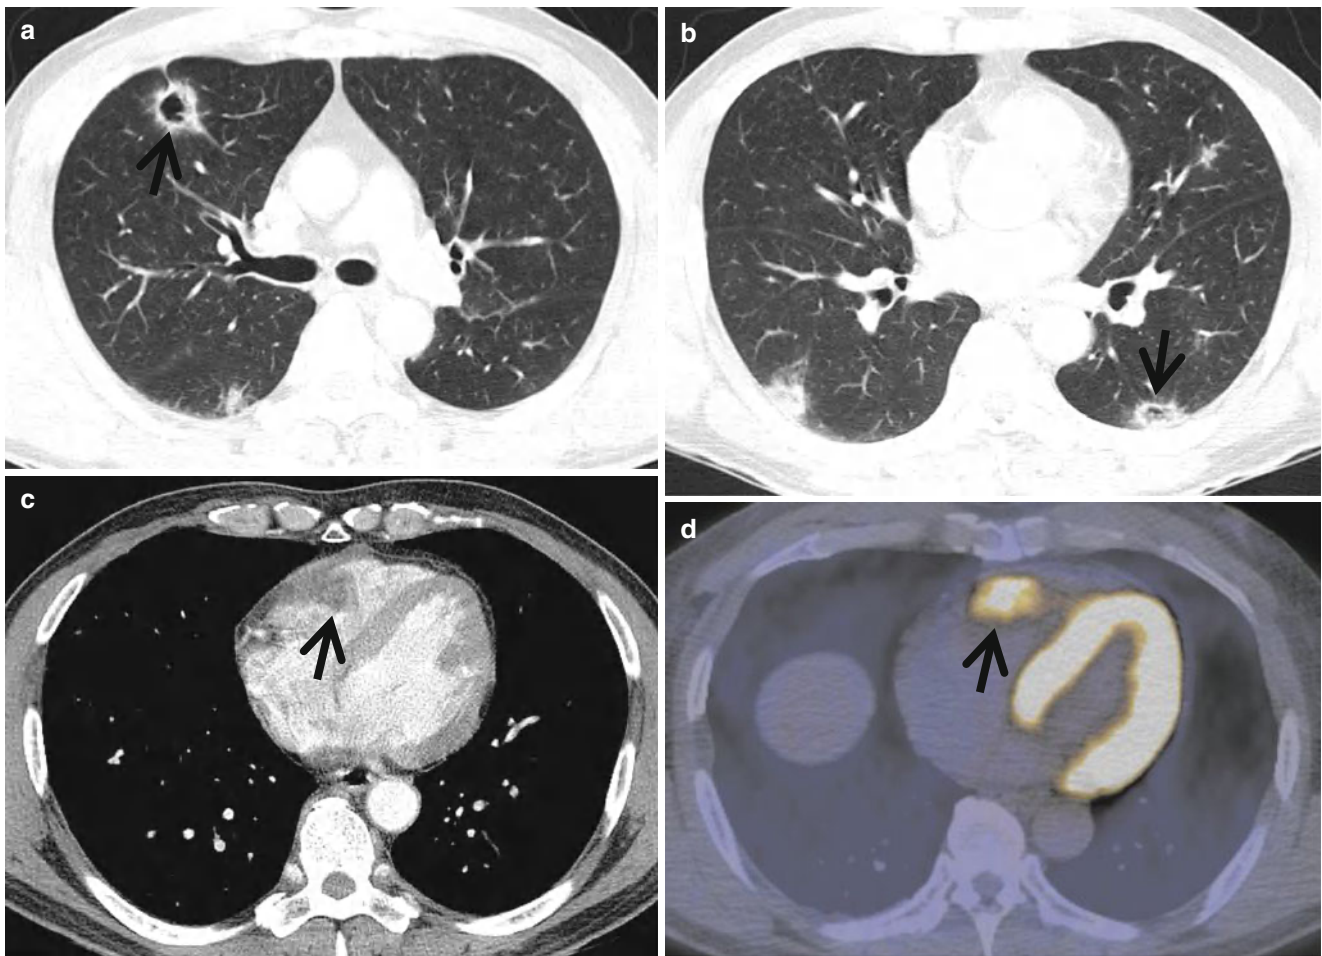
Cavitory lung nodules representing pulmonary metastatic nodules in a 50-year-old man with renal cell carcinoma. (a, b) Lung window images of CT scans (5.0-mm section thickness) obtained at levels of right upper lobar bronchus (a) and basal trunks (b), respectively, show multiple cavitating (*arrows*) and noncavitating nodules in both lungs. (c)
